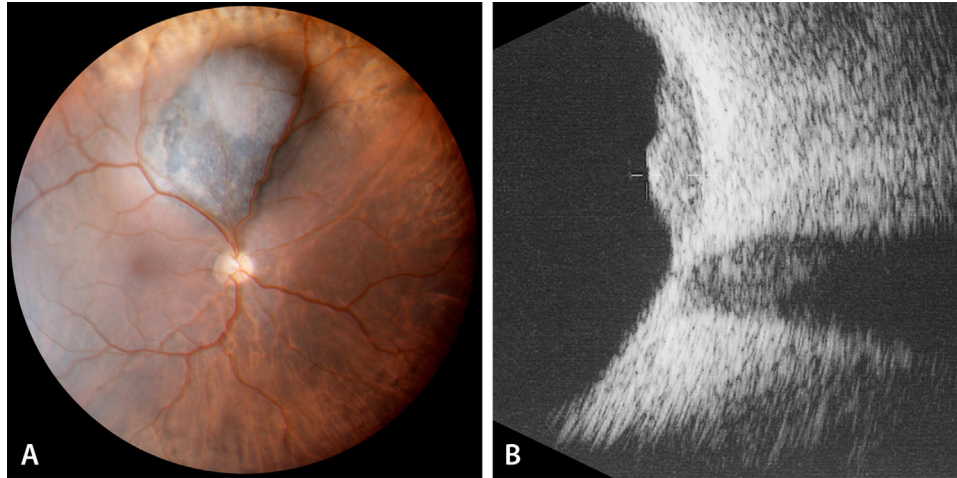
Multinodular choroidal melanoma. (A) Color fundus photography (Panoret-1000, CMT Medical Technologies Inc., Valley Stream, NY) of a binocular partially pigmented mass within the suprapapillary choroid in a 58-year-old female. Orange pigment is present on the surface of the inferior, more pigmented part. The superior lobe has a creamier color. VA = 0.7. Patient had been investigated over the past year and treated with oral steroids by neurologists because of “unexplained” photopsia. (B) On 10 MHz B-scan ultrasonography, the binocular shape can be observed, with a maximal H of 3.2 mm, as well as the infralesional subretinal fluid. H (height). *Courtesy of Dr A Schalenbourg.*
